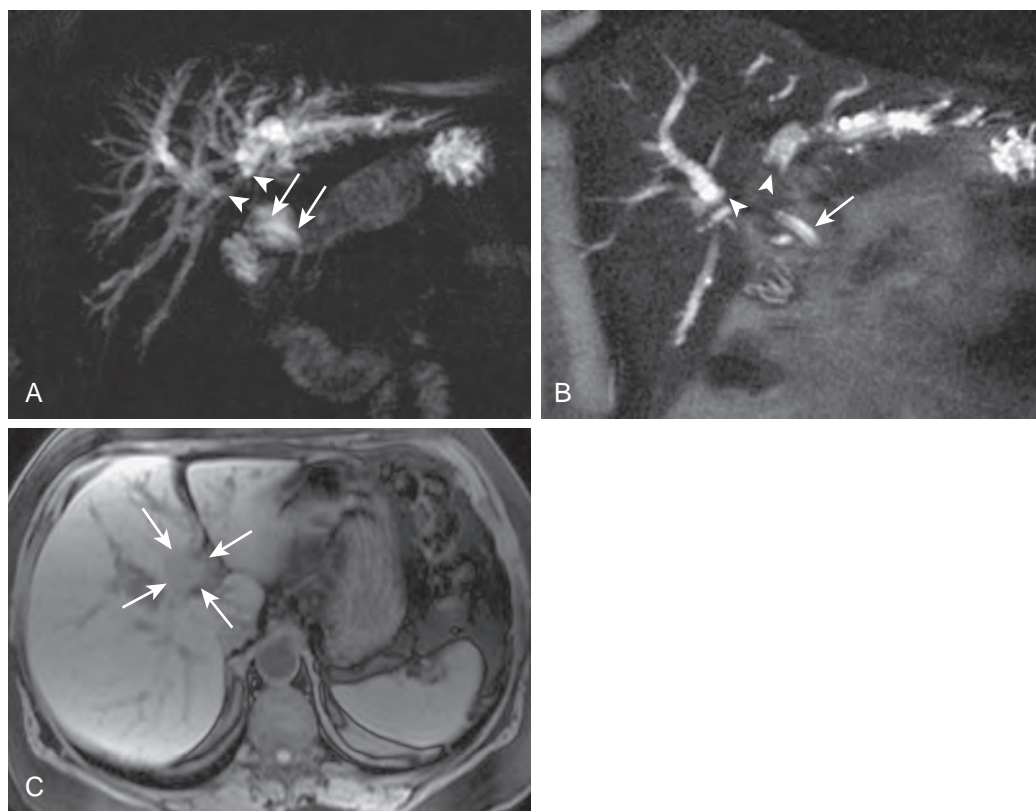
Hilar cholangiocarcinoma. A. Coronal thick-slab MRCP reveals high-grade isolated obstructions of the central right and left hepatic ducts (arrowheads) due to hilar cholangiocarcinoma. The extrahepatic bile duct distal to the obstruction (arrows) is seen adjacent to the fluid-filled duodenal bulb. B. Thin-slab MRCP reveals in greater detail the points of obstruction of the central right and left hepatic ducts (arrowheads) due to cephalad extension of the hilar cholangiocarcinoma. The normal-caliber extrahepatic bile duct (arrow) located just distal to the tumor is noted. C. T1-weighted, fat-suppressed, unenhanced abdominal MRI reveals low signal intensity tumor (arrows) that has extended beyond the confines of the biliary tract to invade the hepatic parenchyma.
